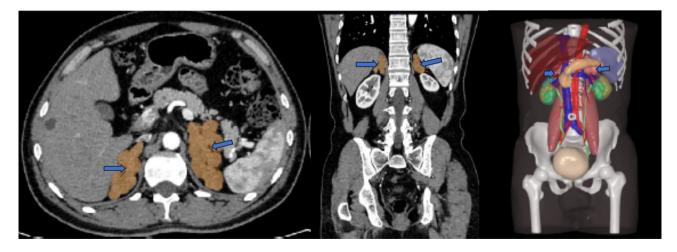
CT examination revealed multiple adrenal nodules, many of which were larger than 1 cm in diameter. Blue arrows point to bilateral adrenal multiple nodules
